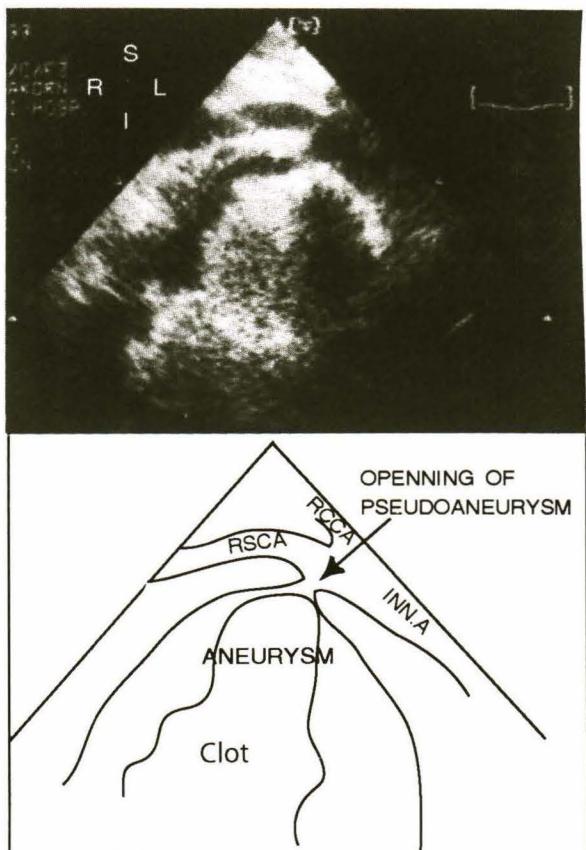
Echocardiogram in suprasternal notch view showing a large pseudoaneurysm with its opening from the right subclavian artery (RSCA). A large clot in the aneurysm is demonstrated as a hyperechoic mass. The BT shunt is not visualized in this frontal plane because it was partially dehiscent and no flow across the shunt. RCCA = right common carotid artery; INN.A = innominate artery.
